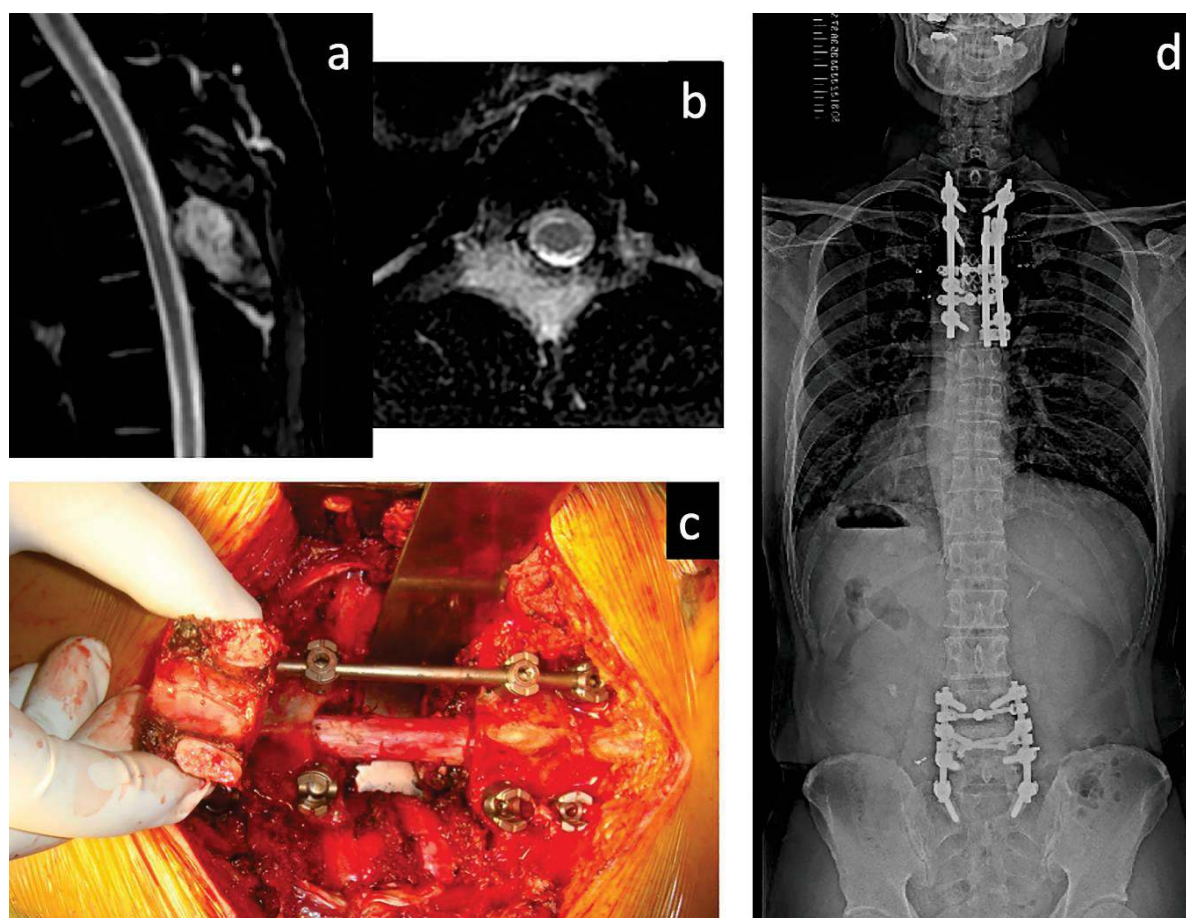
A 39-year-old man diagnosed with multiple lung and spinal metastases of T4 and L4. He underwent metastasectomies for spinal lesions. He also underwent radioactive iodine (RAI) therapy after the spinal metastasectomies and other metastasectomies for BMs, which subsequently appeared in the sacrum, left ilium, and humerus after RAI therapy. Eleven years after the first metastasectomy, he had no local tumor recurrences in the operated lesions; he still performed his normal daily activities and worked without any difficulties. (a) Sagittal and (b) axial T2-weighted magnetic resonance imaging of the thoracic spine, showing metastasis of T4. (c) Spondylectomy of T4 (complete resection of the tumor-affected vertebra) without any significant perioperative complications. (d) A recent full-spine radiography showing good maintenance of the reconstructed spine.
